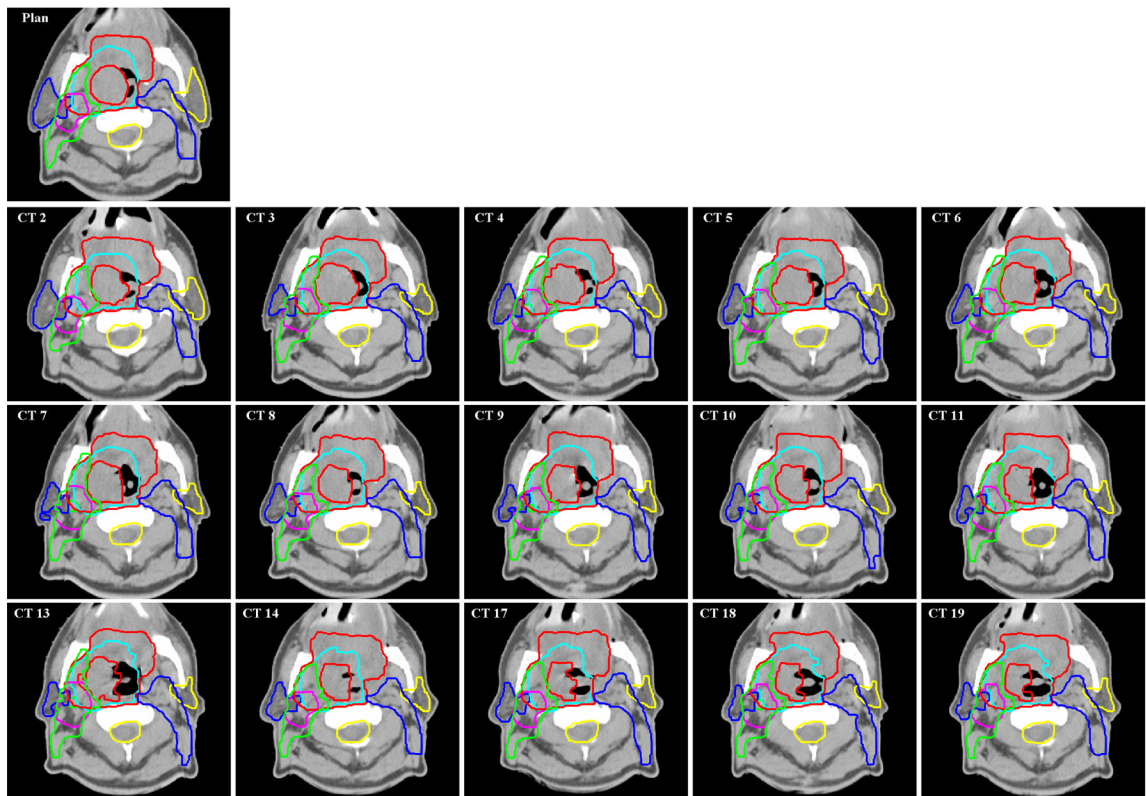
Contours obtained for a head-and-neck patient. Original contours were drawn on the “Plan” CT image. They were transformed automatically by the auto-contouring algorithm to repeat CT images “CT 2”, “CT 3”, ..., “CT 19”.
